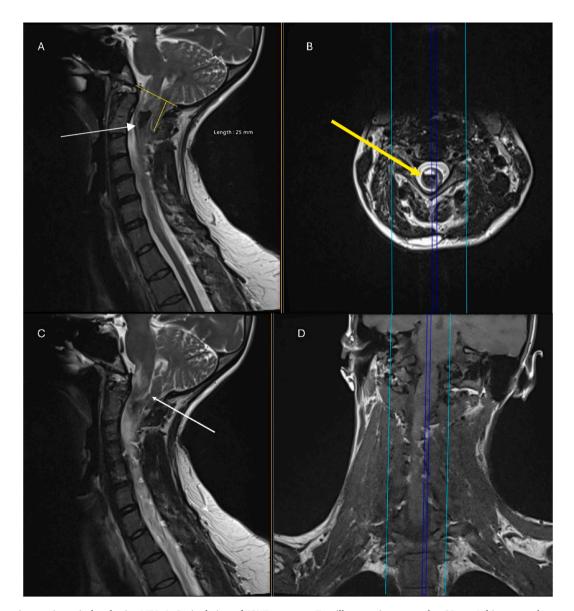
Pre-operative craniocervical and spine MRI. A. Sagittal view of T2WI sequence. Tonsillar ectopia measured at 25mm. White arrow shows syrinx within the spinal cord, with mixed signal, low intensity cephalic, isointense caudally B. Axial view of T2WI sequence at the level of the superior endplate of C4. Yellow arrow shows the fluid level in the syrinx. C. Sagittal view of T2WI sequence. White arrow shows the obex of the cerebellum. D. Respective coronal view for localization.
